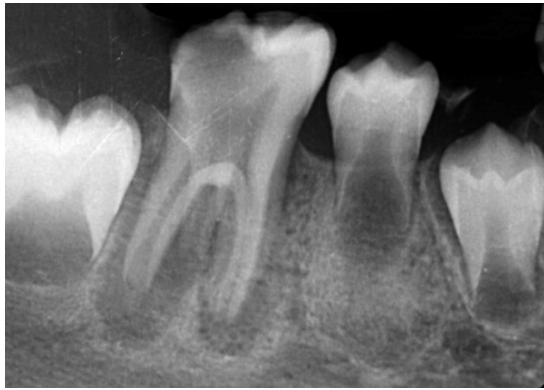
Preoperative radiograph of tooth #30 showing apical radiolucencies in mesial and distal roots, incomplete root development, and the presence of a third root (radix entomolaris)
